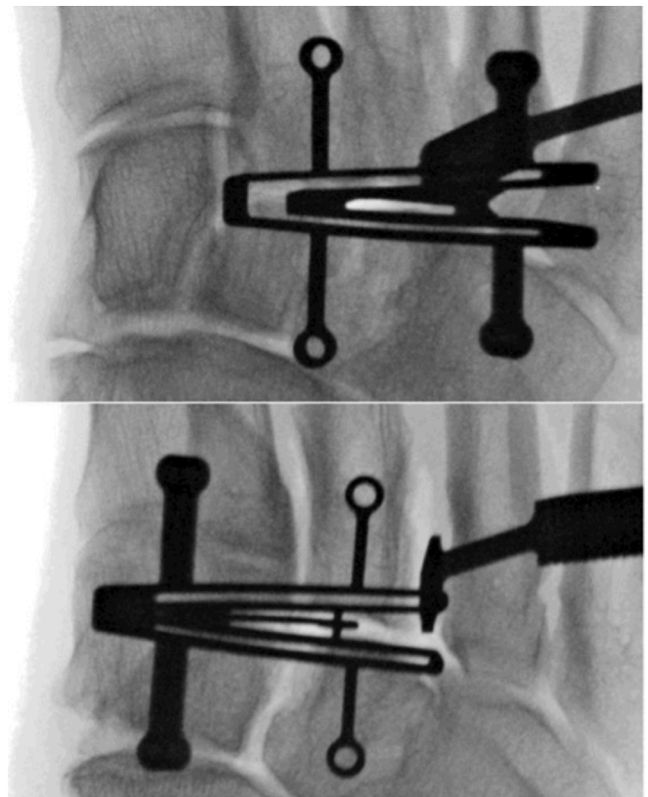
Radiographic appearance of cut guide over second (top) and third (bottom) tarsometatarsal joints.
